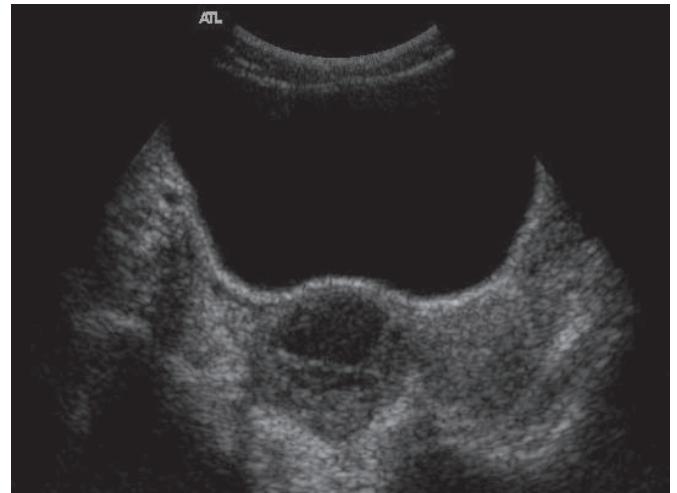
A follow-up ultrasound on the fourteenth day shows a significant decrease in the size of the lesion with minimal residual fluid.
